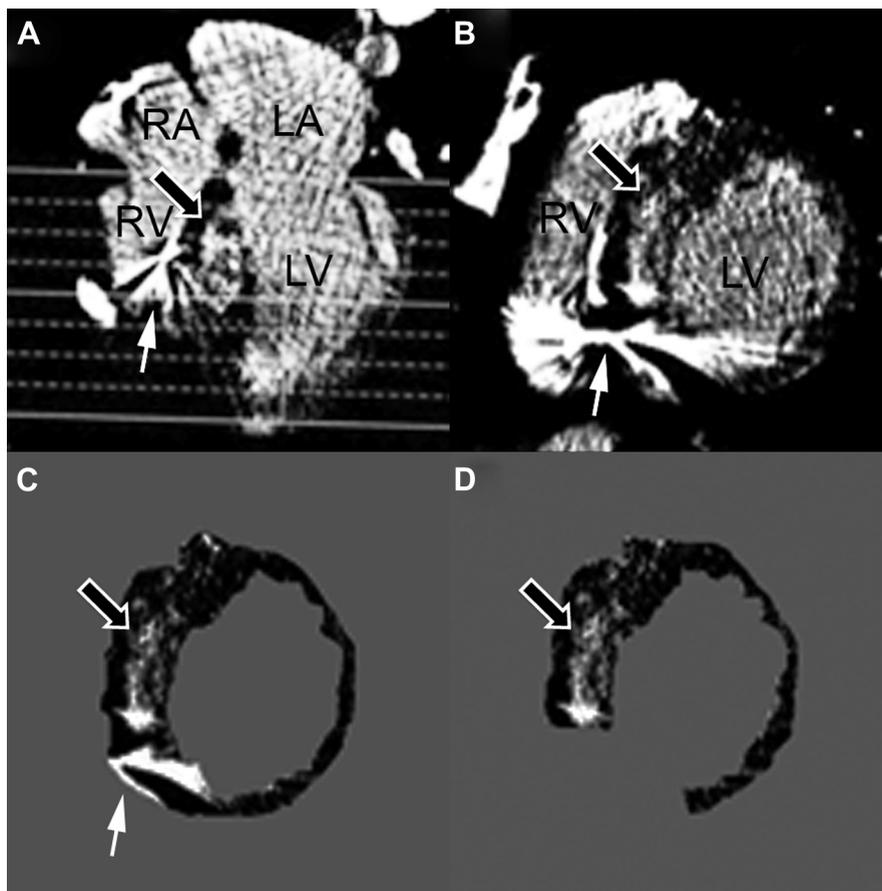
Image analysis for determination of myocardial fibrosis. Delayed cardiac CT images in 4-chamber (A) and short-axis (B) views show septal hypertrophy associated with myocardial hyperenhancement (black arrow). Metal artifact caused by implantable cardioverter defibrillator lead (white arrow) precludes the analysis of inferoseptal left ventricular segment. (C) Segmentation of the LV is shown in the short-axis view. (D) Exclusion of the inferoseptal left ventricular segment. LA, left atrium, LV, left ventricle, RA, right atrium, RV, right ventricle.
